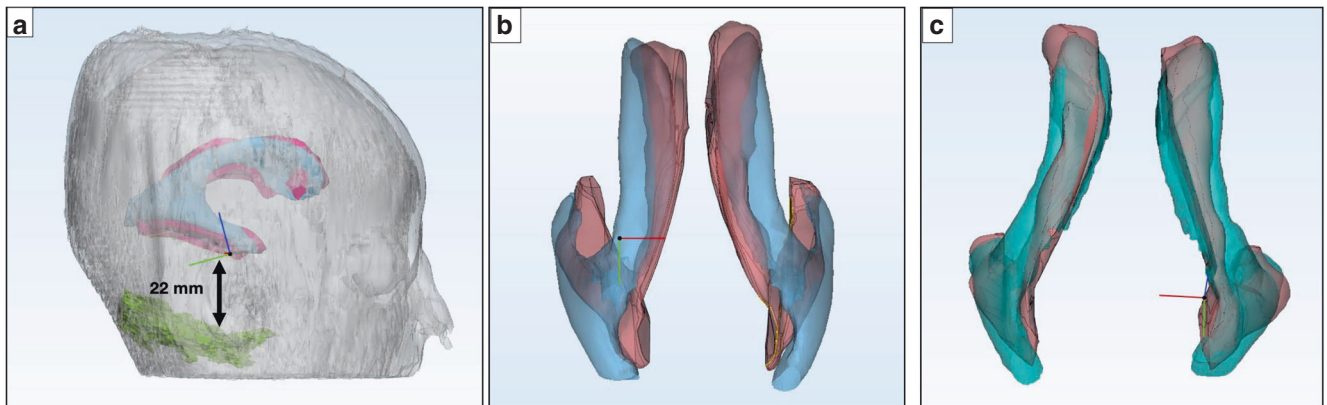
Comparative analysis of the data set of patient H1. a 3D MRI and 3D ultrasound-derived ventricular dimensional validation showing an average distance of 22 mm from the base of the skull, b combined ventricular overlap between 3D MRI (red) and 3D ultrasound (blue), c individual right and left ventricular overlap between 3D MRI (red) and 3D ultrasound (turquoise).
